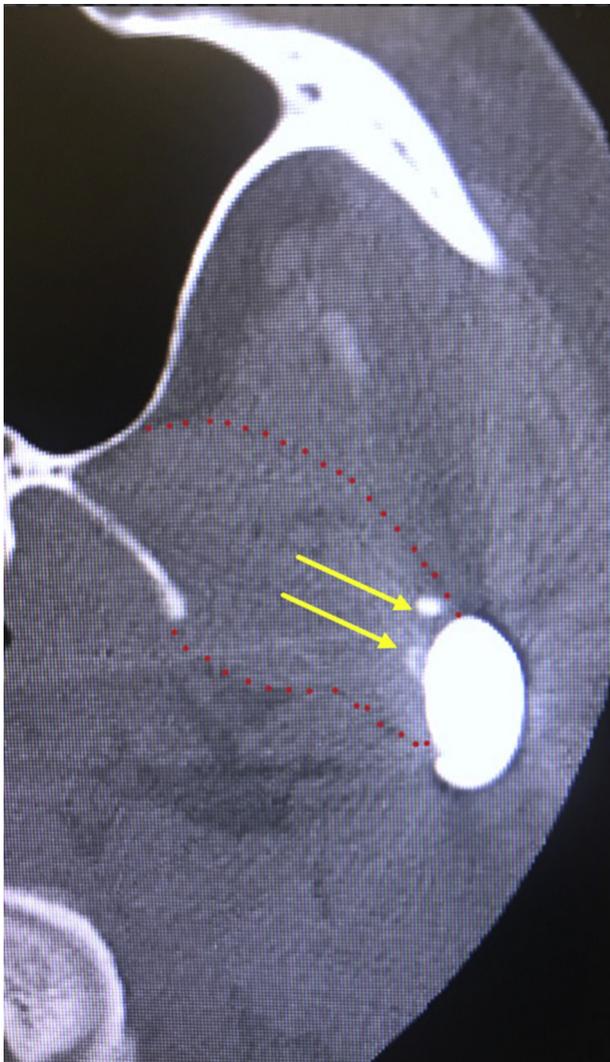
Axial cone beam computed tomogram (CBCT) of patient 2, showing the right side of the mandible at the level of the enthesis. Red dots mark the lateral pterygoid muscle. Yellow arrows indicate the bony part of the enthesis fused to the bone in the scaffold.
